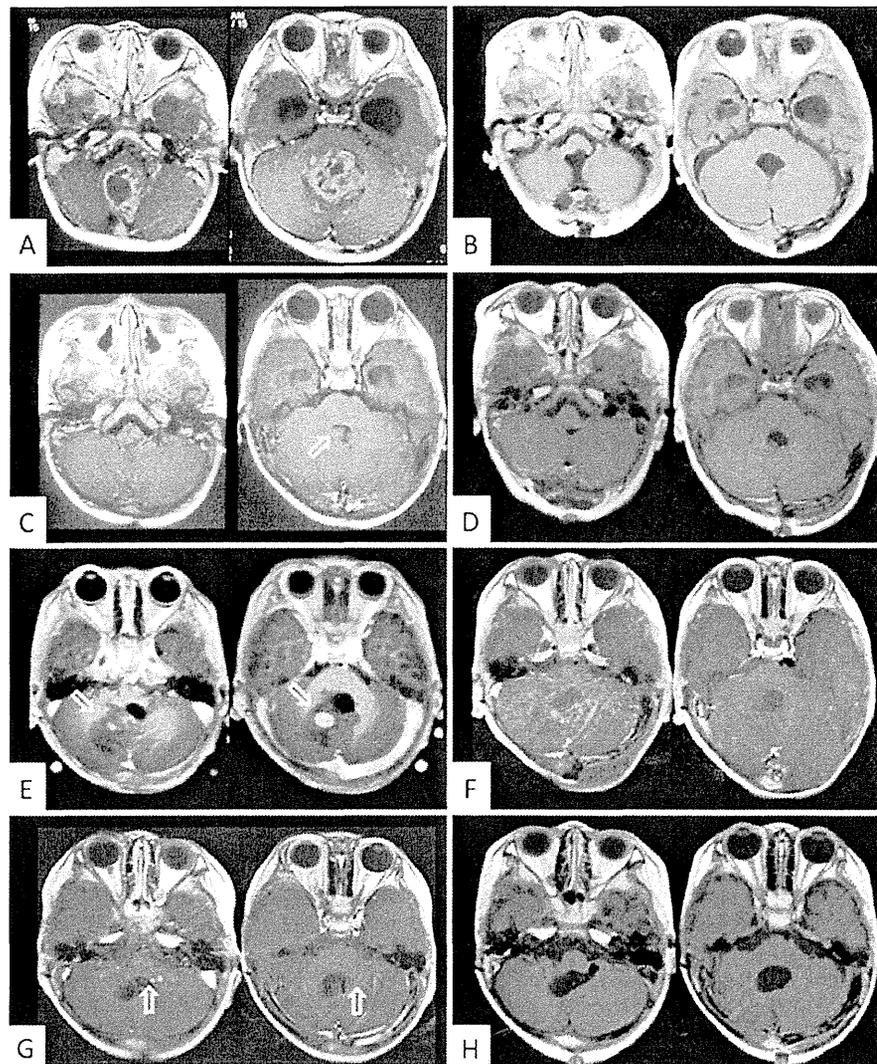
Representative case of a 1-year-old boy with an anaplastic ependymoma successfully treated with 4 surgeries. Admission Gd-enhanced T1-weighted MR images showing a heterogeneously enhanced tumor located in the fourth ventricle (A) and after the first surgery resulting in gross-total removal (B). Gadolinium-enhanced T1-weighted MR images 1 year after the first surgery showing local recurrence (C, open arrow) and after the second surgery resulting in gross-total removal (D). Gadolinium-enhanced T1-weighted MR images 1 year after the second surgery showing another mass lesion in the right cerebellum (E, open arrows) and after the third surgery resulting in gross-total removal (F). Follow-up Gd-enhanced T1-weighted MR images 2 years after the third surgery revealing a small enhanced lesion in the left lateral recess (G, open arrows) and after fourth surgery resulting in gross-total removal (H).
